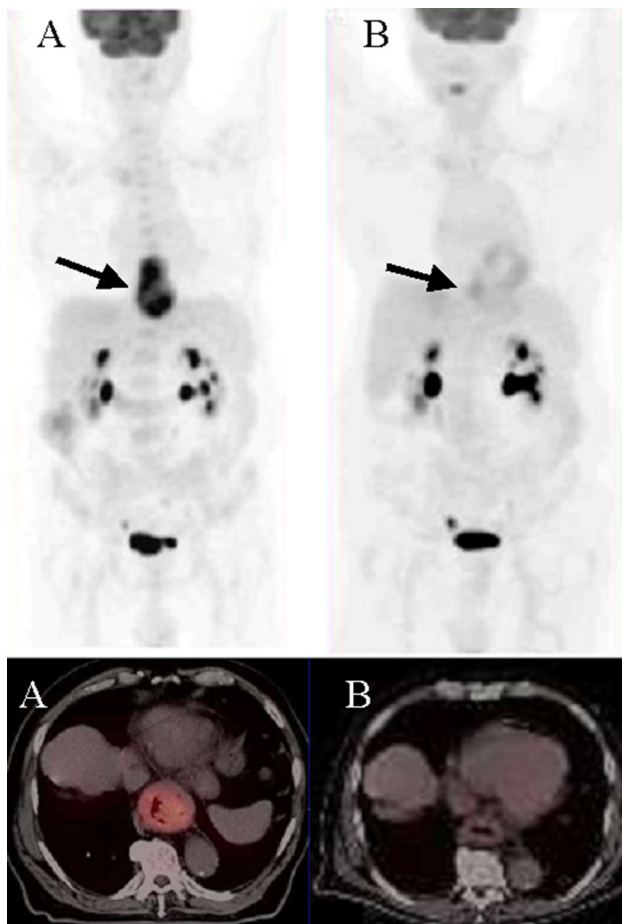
77-year-old man with poorly differentiated squamous cell carcinoma of distal esophagus. PET/CT at baseline (a): marked focal uptake of FDG identified in mid-esophageal tumor (*arrow*). Follow-up PET/CT (b) showing complete metabolic response, with degree of uptake at tumor site indistinguishable from physiological uptake (*arrow*)
